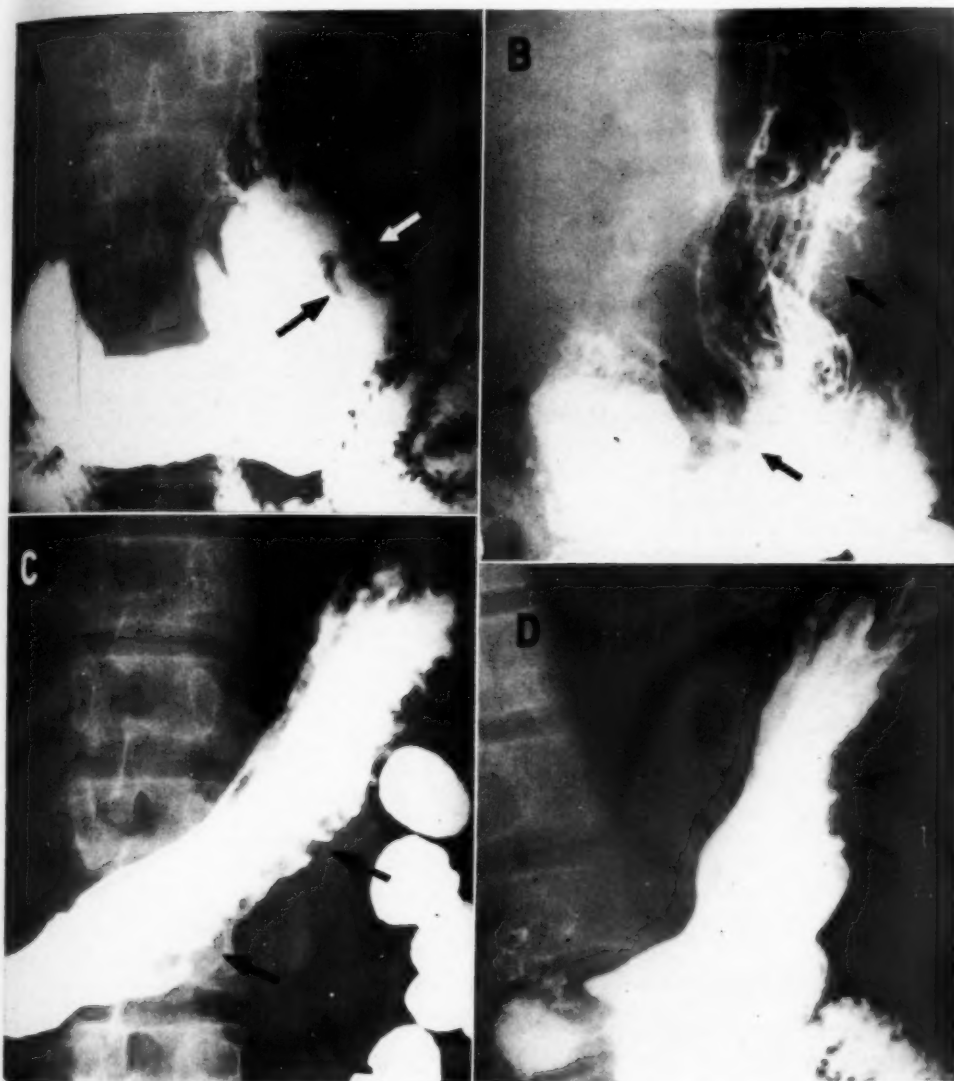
Case 8. A. Marked deformity of the greater curvature with a pressure defect due to distention of the splenic colon. B. Roentgenogram made in erect position showing the extent of the deformity on the greater curvature with a deep penetrating ulcer niche on the lesser curvature of the antrum (arrows). C-D. Case 9. C. Case of duodenal ulceration. Exaggerated serrations or saw-tooth effect of the greater curvature. D. Oblique view showing the deformity of the greater curvature with pseudo-ulcer-niche defects (arrows).
